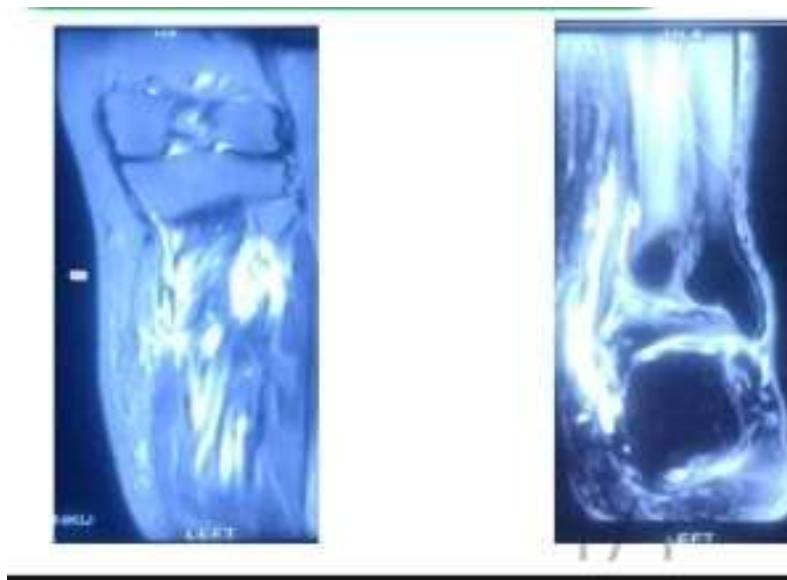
MRI- Engorged venous malformation
